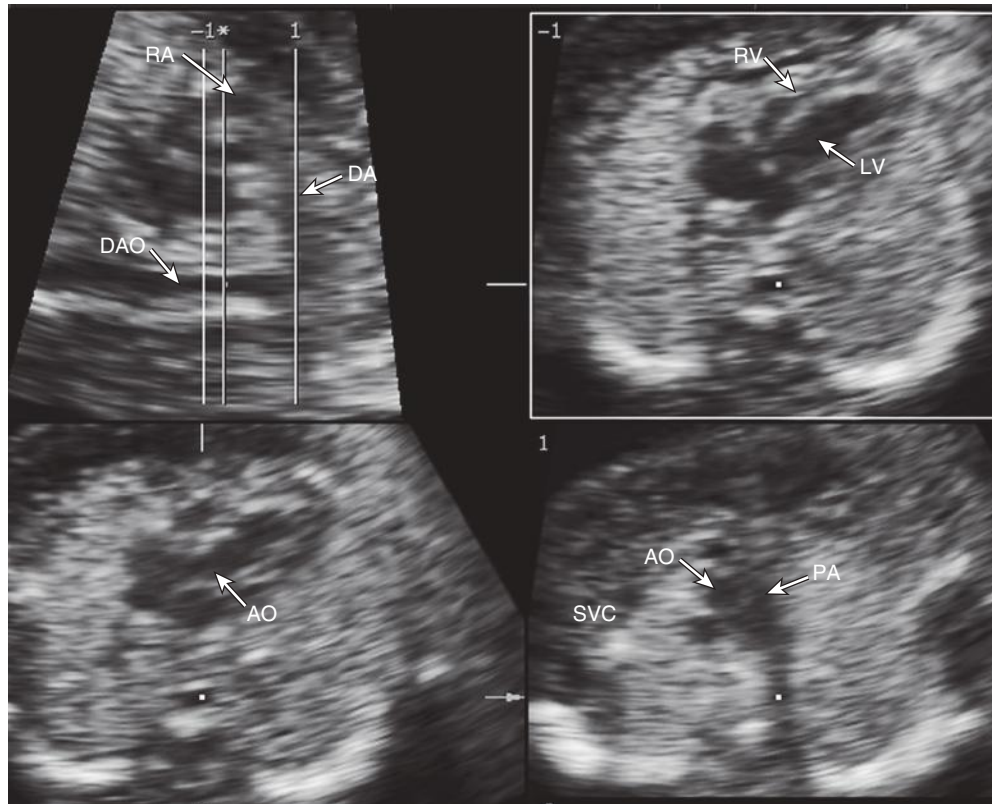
Early gestation imaging of tricuspid atresia. Tomographic ultrasound imaging in a fetus with tricuspid atresia and normally related great arteries at 12 $\frac{5}{7}$ weeks of gestation. The image on the upper left corner corresponds to the ductal arch plane. The four-chamber view is displayed on upper right corner, which demonstrates a small right ventricle (RV); the five-chamber view is displayed in lower left corner. A very small pulmonary artery (PA) is seen on the three-vessel view. AO, aorta; DA, ductus arteriosus; DAO, descending aorta; LV, left ventricle; RA, right atrium; SVC, superior vena cava.
